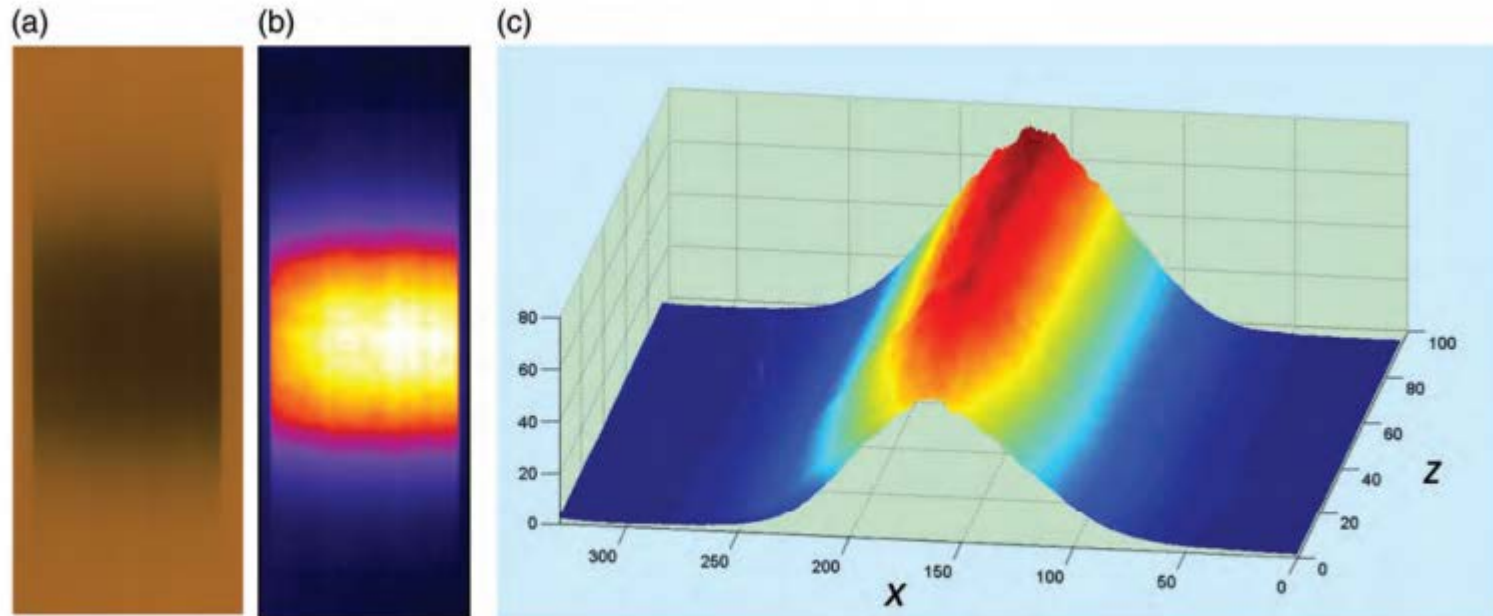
Use of radiochromic self-developing film to determine the relative two-dimensional distribution. A photograph of the self-developing film exposed at the isocenter of the CT scanner is shown in (a). The analog film was digitized, and the red channel was used with appropriate characteristic-curve normalization to determine the relative two-dimensional radiation-intensity distribution, shown in (b). An isometric plot of the distribution is shown in (c).
